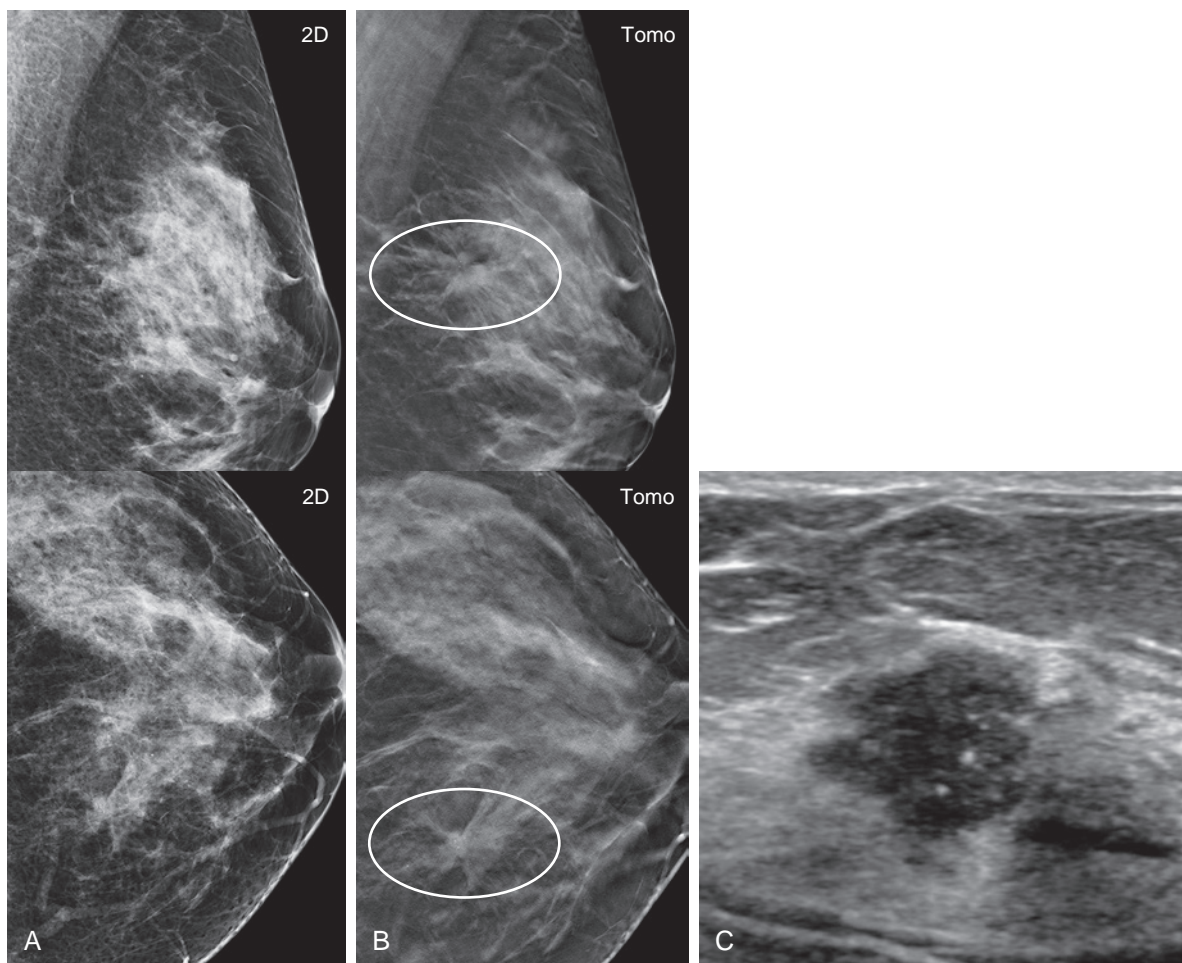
Architectural distortion. (A) 46-year-old woman with heterogeneously dense breasts was recalled from screening for architectural distortion in the left breast at the 11-o'clock position, (B) more clearly shown on tomosynthesis images (*ovals*). (C) Subsequent ultrasound correlate was found. Ultrasound-guided core needle biopsy and excision indicated invasive ductal carcinoma, T1cN0, ER/PR/Her2+.
